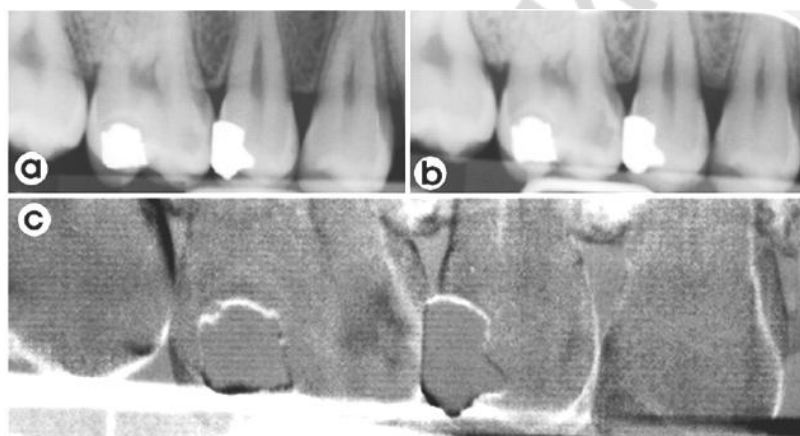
Example of a subtraction of two digital bitewing radiographs: *a* — radiograph showing proximal lesion on mesial surface of first molar; *b* — follow-up radiograph taken 12 months later; *c* — the areas of difference between then two films are shown as black, i.e. in this case the proximal lesion has become more radiolucent and hence has progressed
